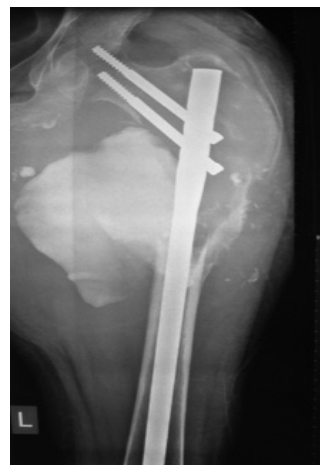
Antero posterior radiograph of the proximal femur revealed progression of the lytic lesion in bone
